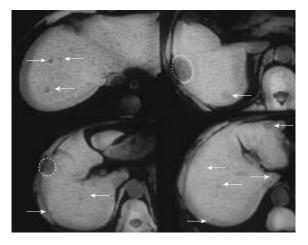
Angio-computed tomography findings. Preoperative image study revealed multiple liver metastases (white arrows) except for segment 4. She underwent the partial hepatectomy of segment 6 at initial surgery (white dotted circle).
